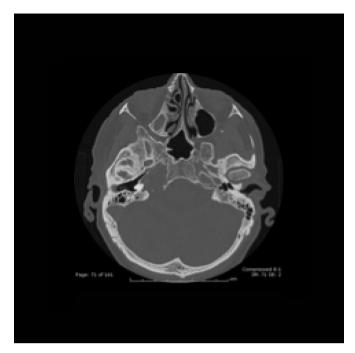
Axial CT scan of the head (bone window) of Patient 1 showing destruction of the petrous ridge and to some extent the clivus on the right side.
